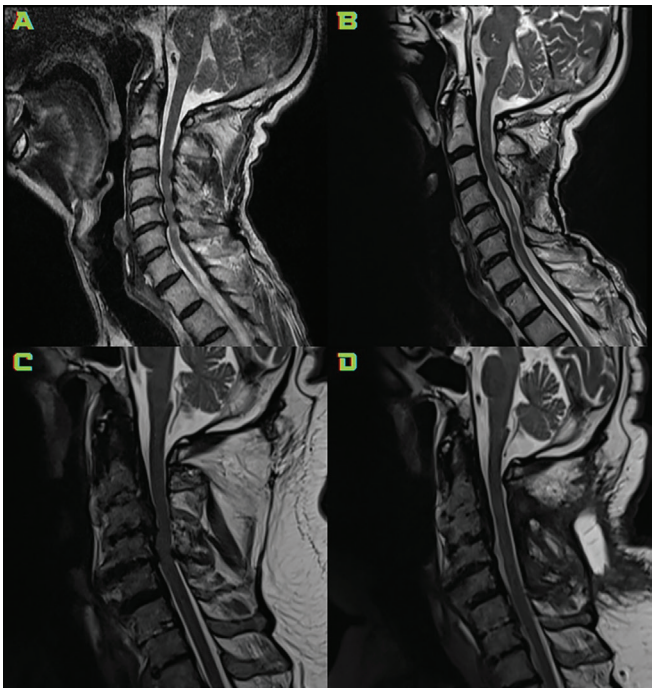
The preoperative and postoperative MRI images of 2 patients with cervical spondylotic myelopathy undergoing cervical laminectomy without fusion are shown
